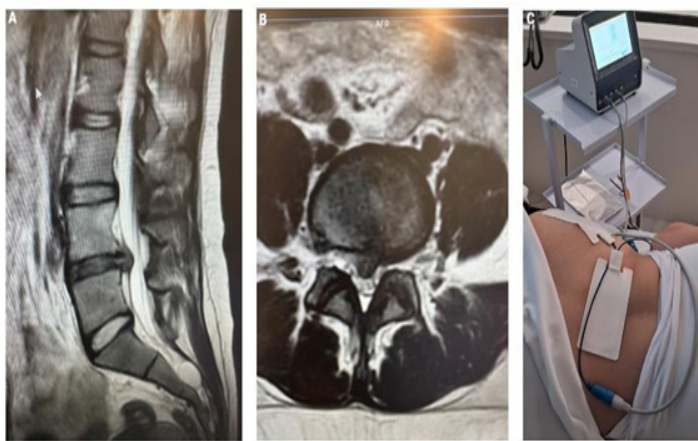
A) MRI revealed a large disc herniation at L4-5; B) Central canal compression; C) TC-PRF patches application for lumbar disc herniation with left limb irradiation.
